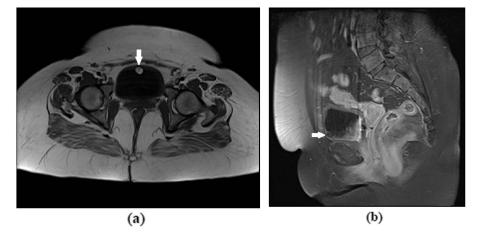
An intramural mass lesion with (a) markedly high signal characteristics in axial T1-weighted images and (b) suppressed characteristics in sagittal fat-suppressed T1-weighted images.
